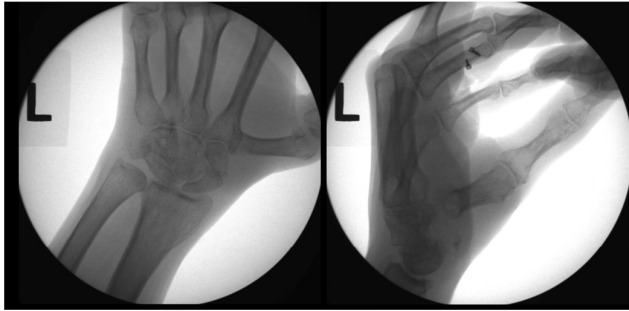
Intraoperative radiograph with axial traction applied to the thumb demonstrating complete trapeziectomy and lack of osteophytes between thumb and index metacarpals
